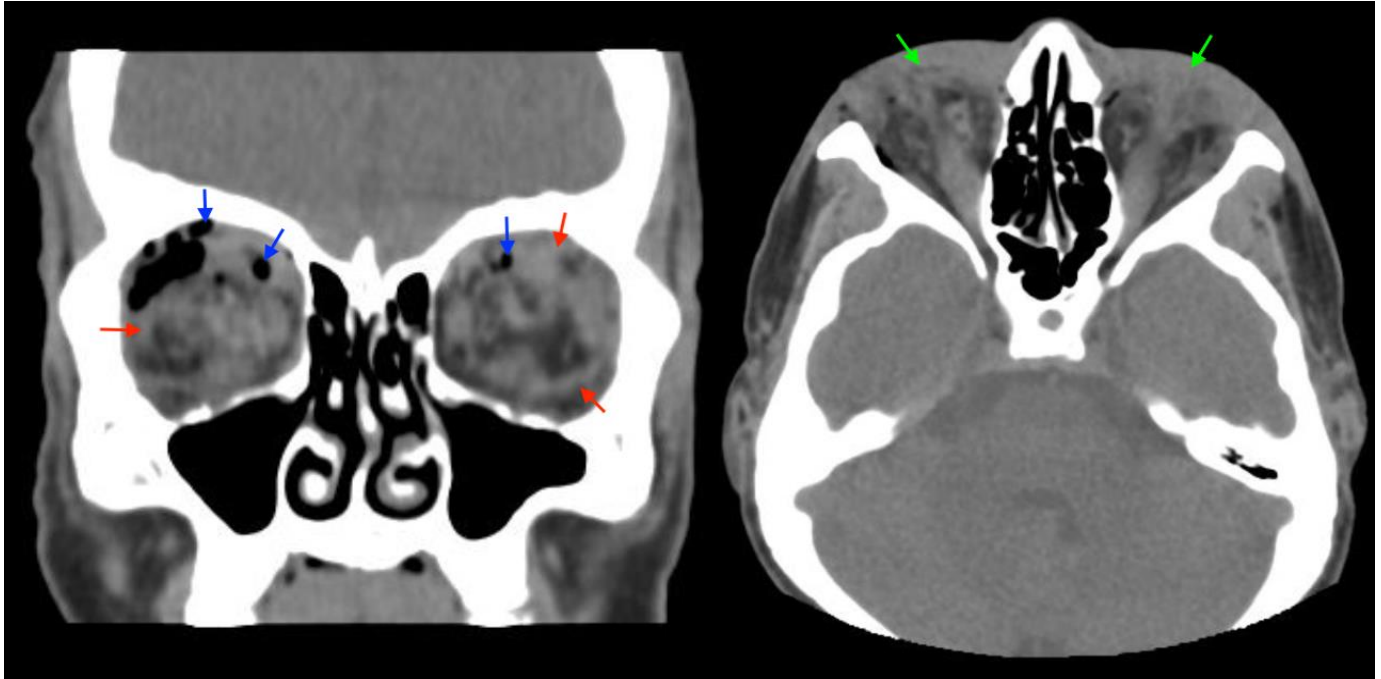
Non-contrast computed tomography of the orbits shows the absence of eyeballs (green arrows), edema (red arrows), and emphysema (blue arrows) in the orbital cavities.
